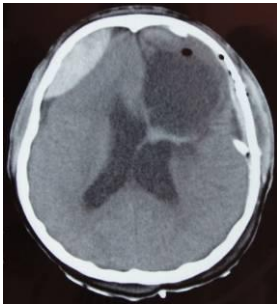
Postoperative first day, CEDH was observed on a control CT scan. The conservative treatment was preferred to second surgery due to absent of the shift effect in midline and well neurological status of patient.
